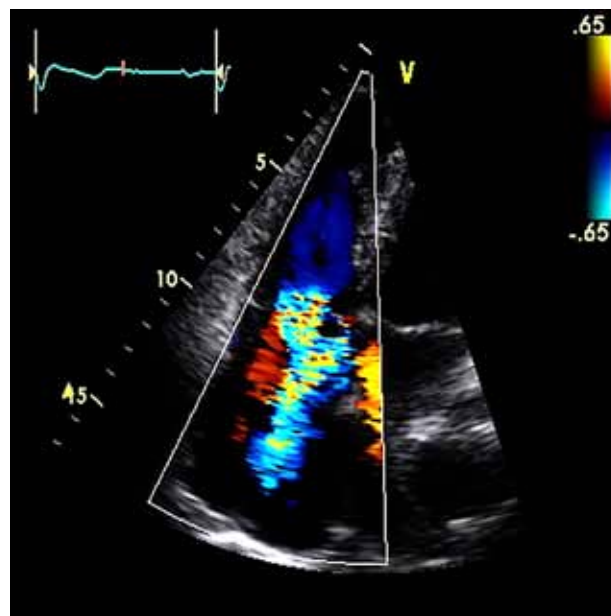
Moderate tricuspid regurgitation demonstrated with colour Doppler imaging.
